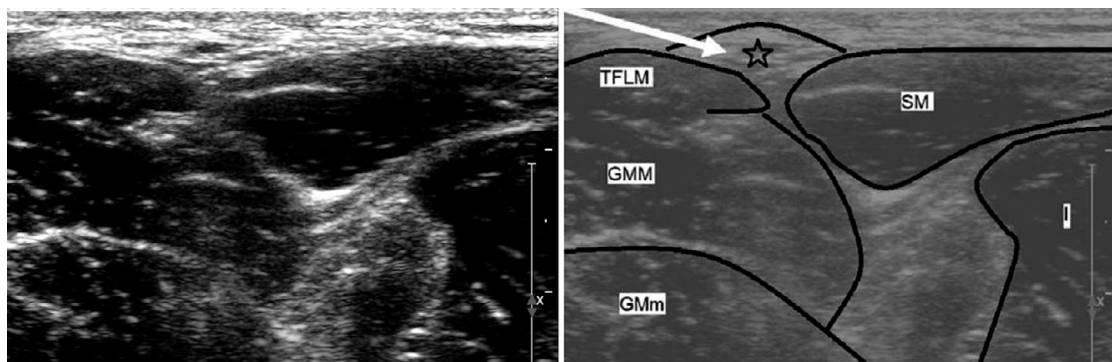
Ultrasound appearance of the lateral cutaneous nerve of the thigh (☆), tensor fascia lata muscle (TFLM), gluteus maximus (GMM), gluteus medius (GMm), sartorius (SM) and iliacus (I).
